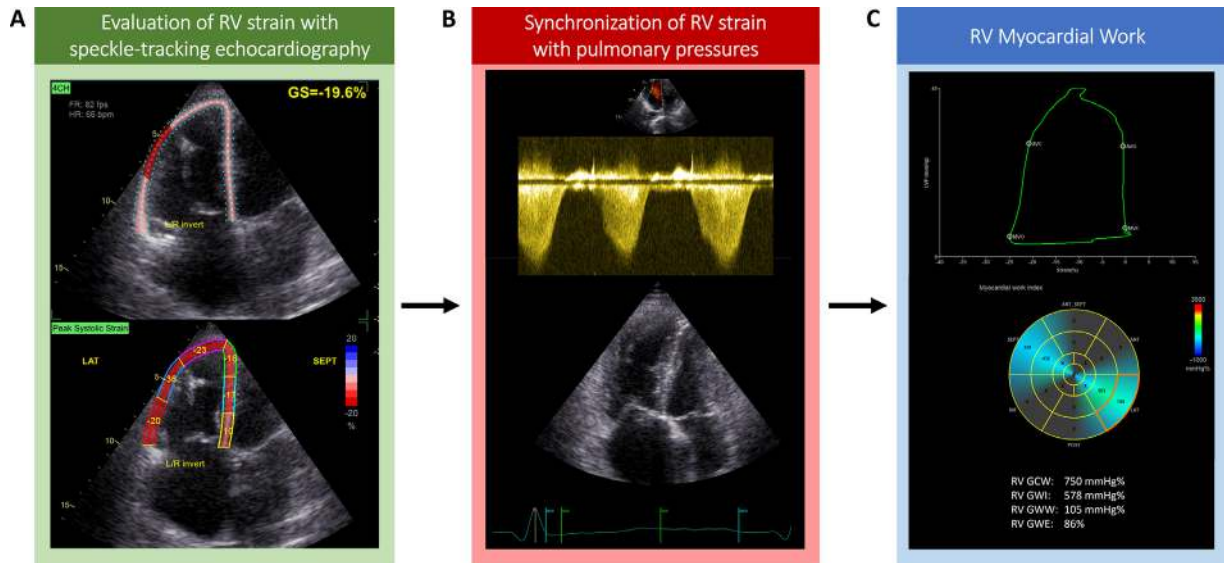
Method of acquisition of RV myocardial work parameters. RV myocardial work incorporates speckle-tracking echocardiography-derived RV strain, pulmonary pressures, and cardiac valve opening and closure events to generate noninvasive pressure-strain loops of the right ventricle. Panel A depicts the acquisition of RV global longitudinal strain utilizing speckle-tracking echocardiography. The upper image in Panel B demonstrates an image used for the estimation of PASP from the TR jet peak velocity using the modified Bernoulli's equation. The lower image in Panel B demonstrates the synchronization of cardiac valvular event timings, performed through either direct visualization of the two-dimensional image presented, or using event timings established by pulsed-wave Doppler interrogation. Panel C demonstrates the noninvasive estimation of RV myocardial work indexes and a pressure-strain loop of the basal segment of the free wall of the right ventricle. TR = tricuspid regurgitation.
